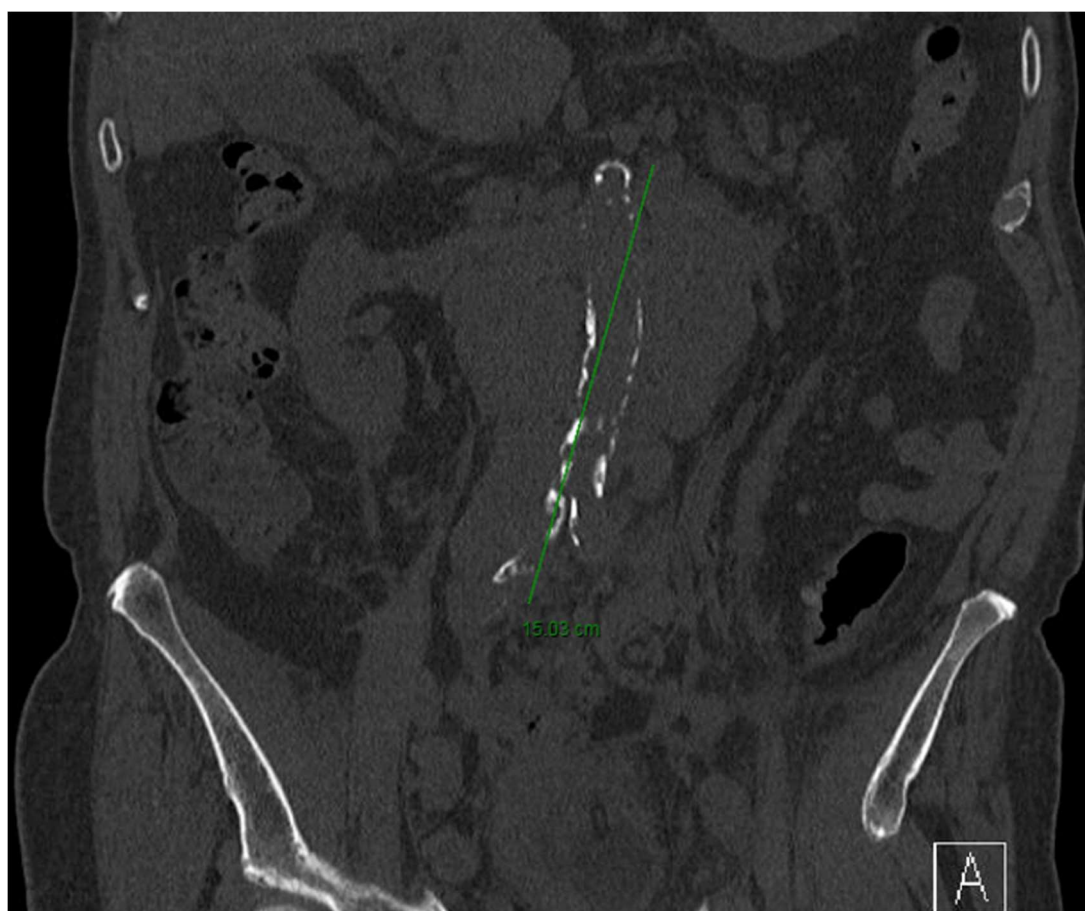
Abdominal CT scan. Antero-posterior view of a large adenopathic block that encircled both ureters and surrounded the aorta and inferior vena cava.
